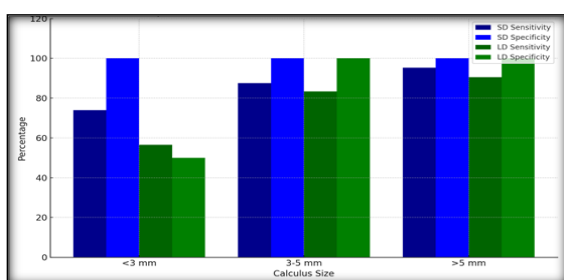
Comparison of Low-dose CT and Standard Dose CT in Detection
